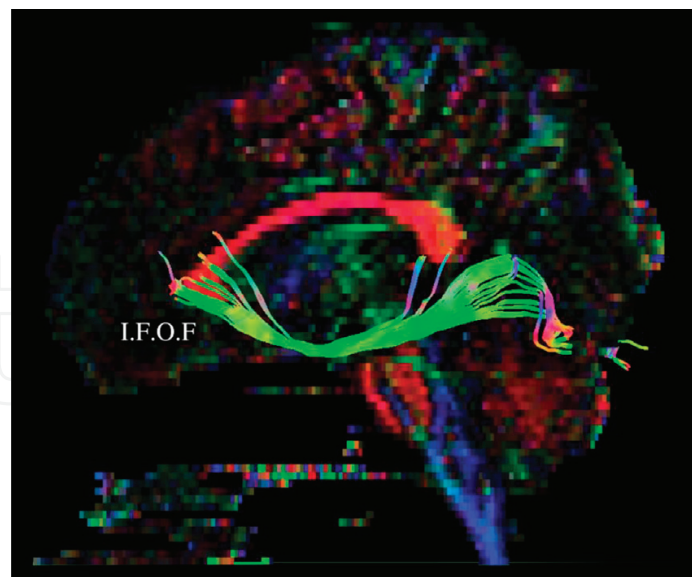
MRI tractography in sagittal view showing inferior fronto-occipital fasciculus (I.F.O.F) fibers.
